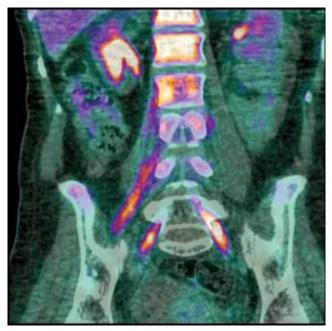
PET/CT scan showing increased ¹⁸F-FDG activity in three nerve roots of the lumbar plexus on both sides of the vertebral column.
